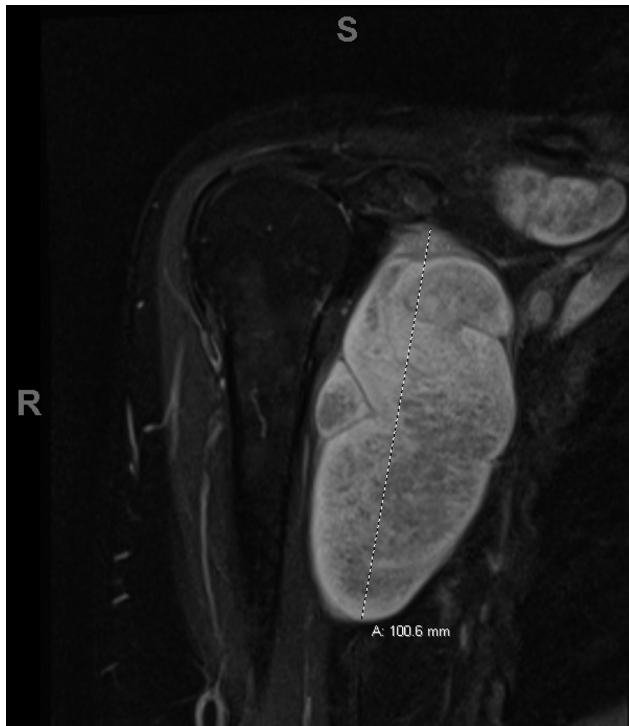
MRI of an axillary Schwannoma located along the course of the brachial plexus interposed between the biceps brachii and pectoralis major muscle and measuring 10 cm X 4.7 cm x 4.6 cm.
